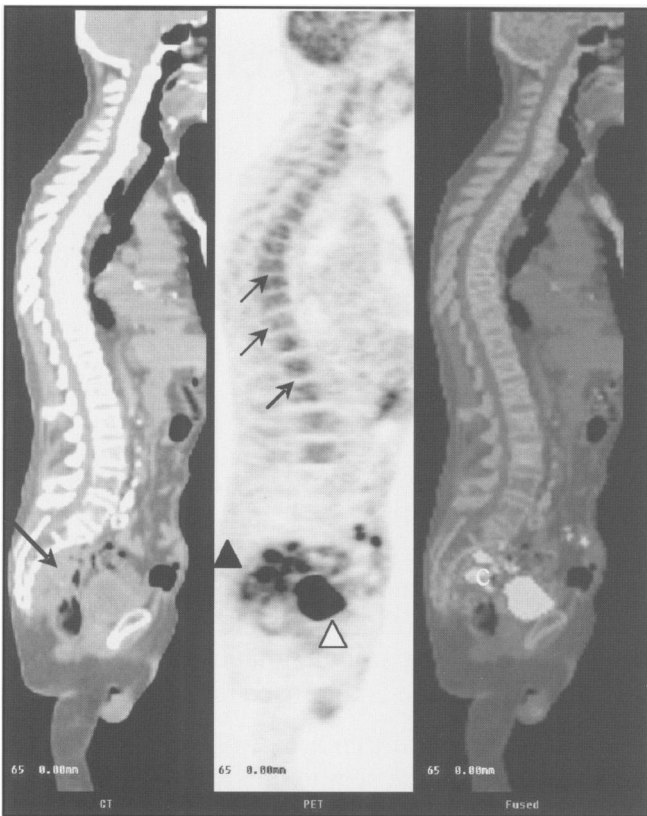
PET-CT (sagittal section) demonstrating a pre-sacral mass with soft tissue density (long black arrow) and abnormal FDG uptake within the pelvis (black arrow head). Note the normal FDG excreted in the bladder (white arrow head). The fused (PET-CT) image shows abnormal activity within the pelvis (c). Also note the increased activity in the spinal bone marrow due to pyrexia and marrow stimulation (short black arrows). Note the absence of marrow in the lumbar spine due to prior radiotherapy.
